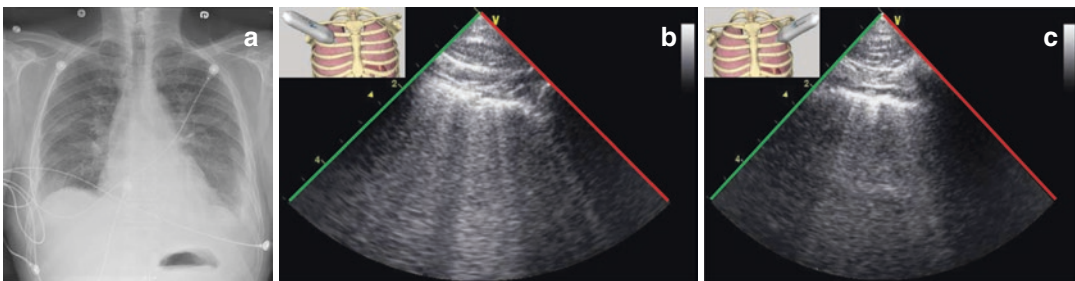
Pulmonary congestion. (a) Chest radiograph of an 86-year-old man and lung ultrasound images (b, c) show diffuse B-lines in zones 1 and 5 (with permission of Denault et al. [82])
